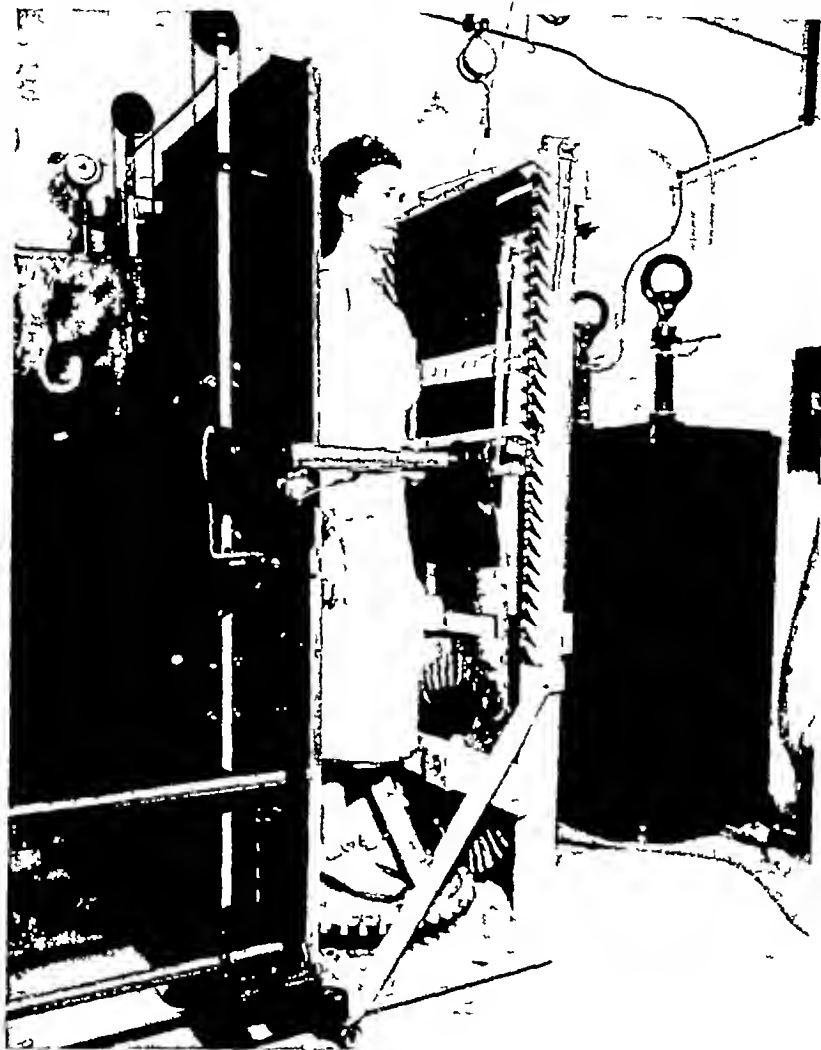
The attachment is mounted for radiography and placed in position for exposures
